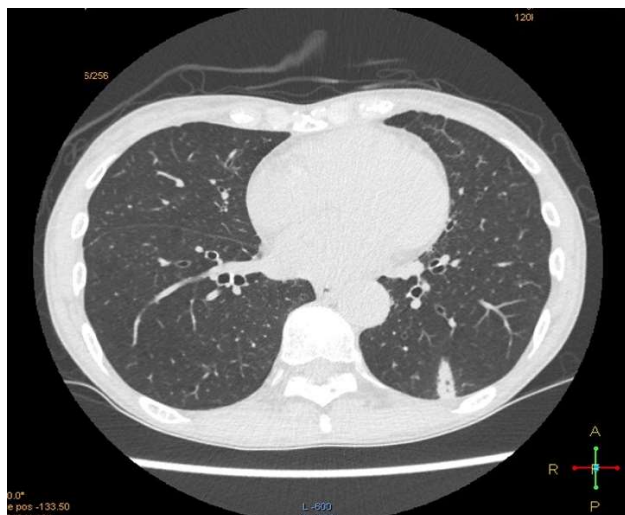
High-resolution chest computed tomography showing patchy opacities compatible with pulmonary septic emboli.
